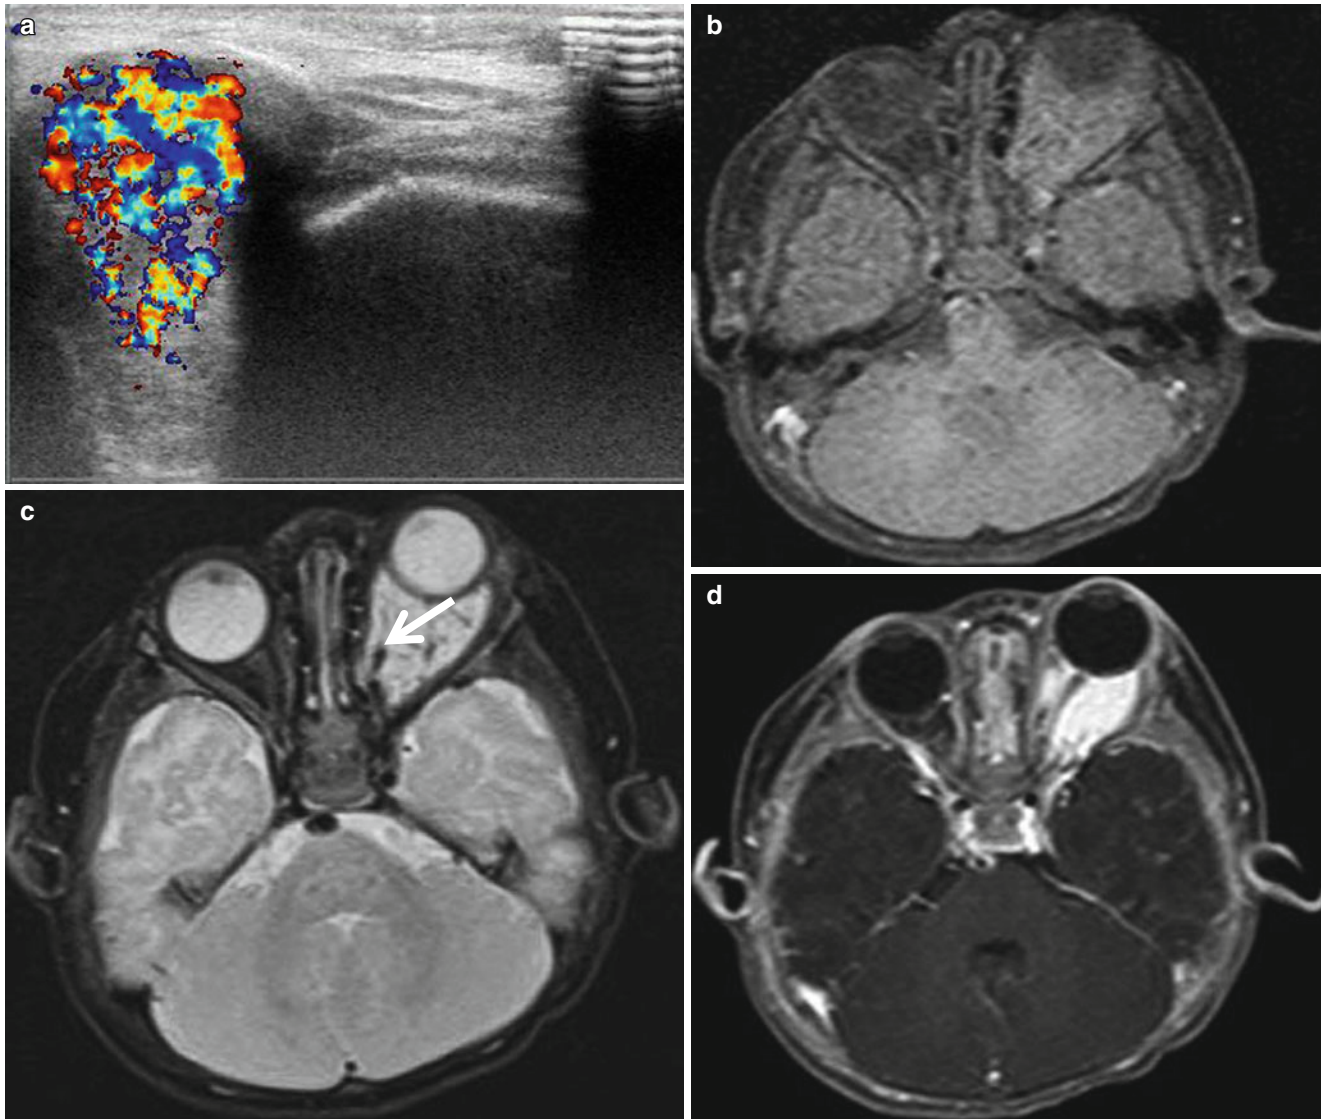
Orbital hemangioma in a 4-month-old infant. (a) Color Doppler US shows a hypervascular solid mass in the right orbit. (b, c) Axial fat-saturated T1- and T2-weighted MR images show a soft tissue mass of homogeneous iso- and high signal intensities relative to the muscle on T1-weighted (b) and T2-weighted (c) images, respectively.
